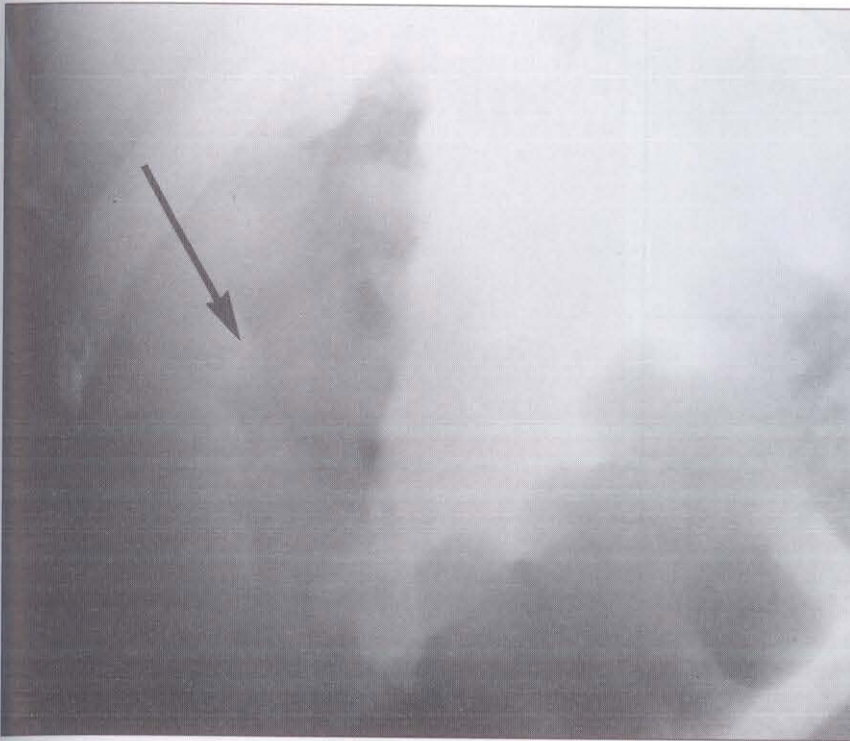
Abdominal x-ray showing thumbprinting (arrow) in the ascending colon
